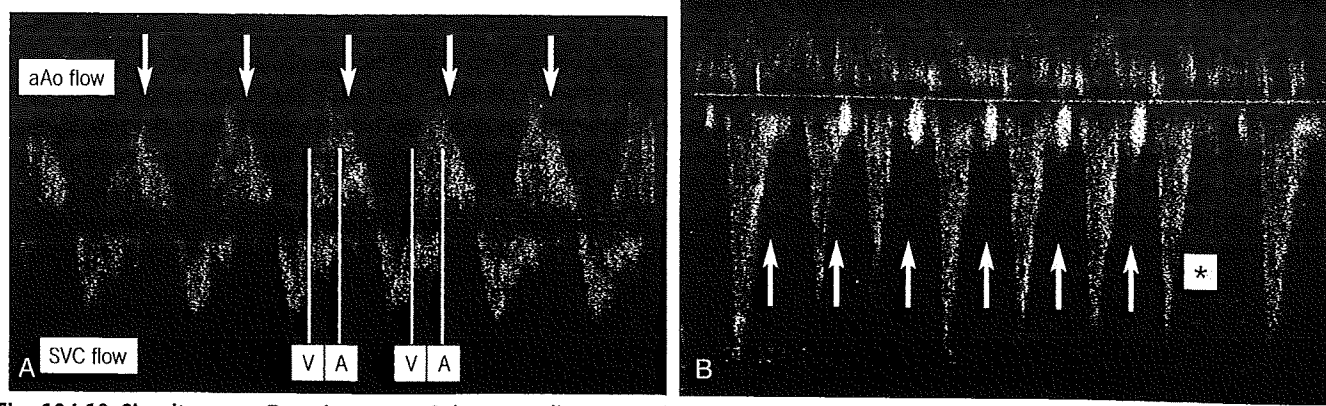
Simultaneous Doppler trace of the ascending aorta (aAo) and the superior vena cava (SVC). A, Doppler trace of a fetus with supraventricular tachycardia with short VA interval. Although high-velocity reversal flow of SVC is almost over-rapped to the flow of Ao, the starting point of the reversal flow can be detected from the interrupted forward flow of the SVC. B, Doppler trace of the fetus with 1:1 atrioventricular conduction tachycardia with long VA interval. Tachycardic atrial contraction (arrows) disappears after the seventh ventricular contraction (*), and the tachycardia is stopped.
